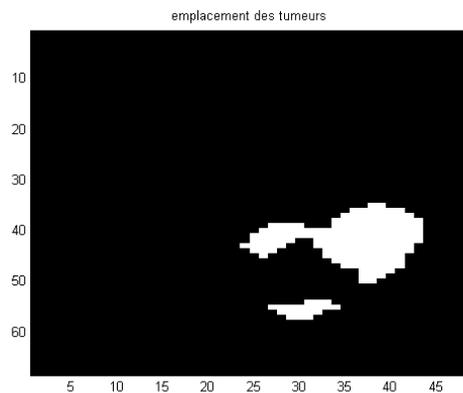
slice where the fixation of the FDG cells is the largest.
